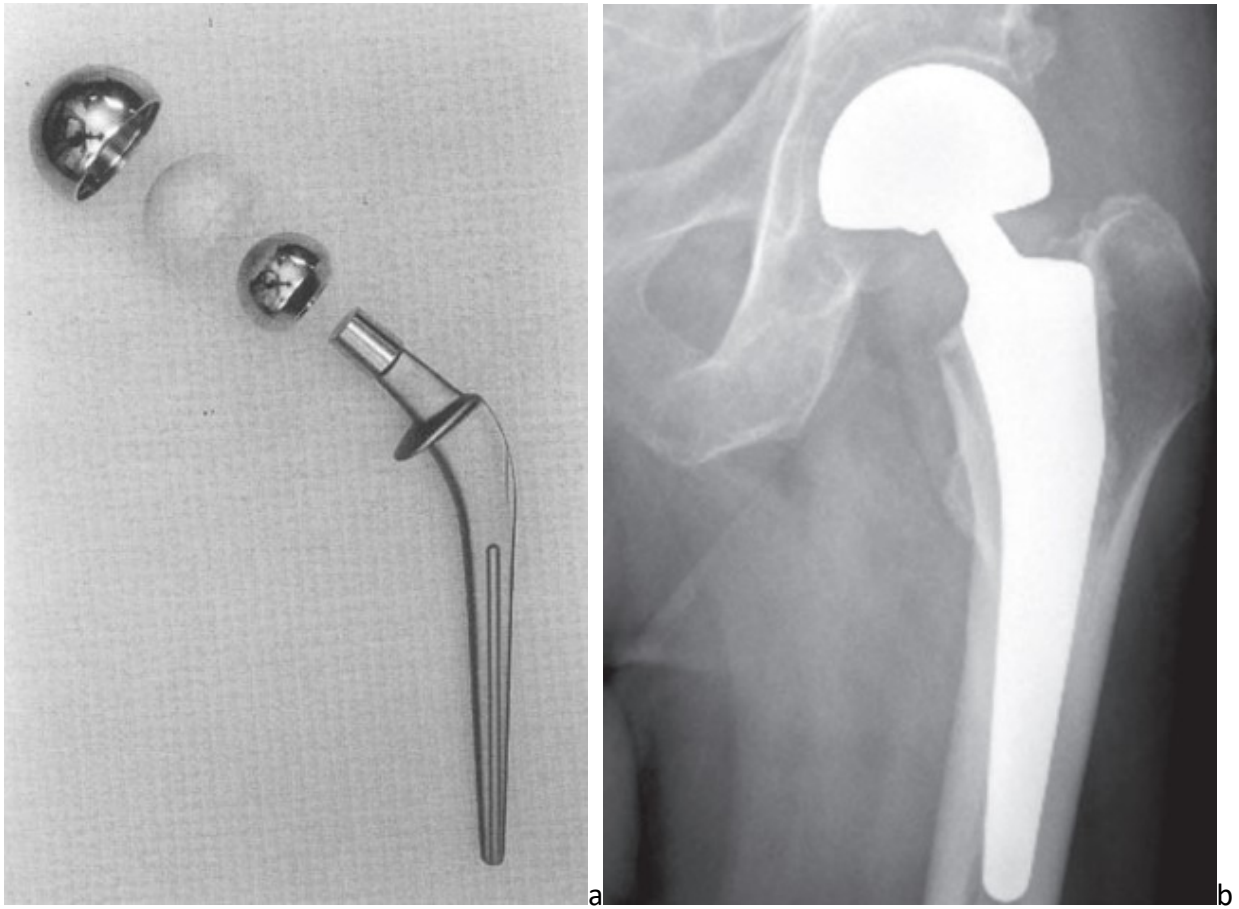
Photograph of a bipolar hip hemiarthroplasty (a) and radiograph of implanted bipolar hip hemiarthroplasty. Reproduced with permission from Springer (licence number: 4450960195677), [14].
